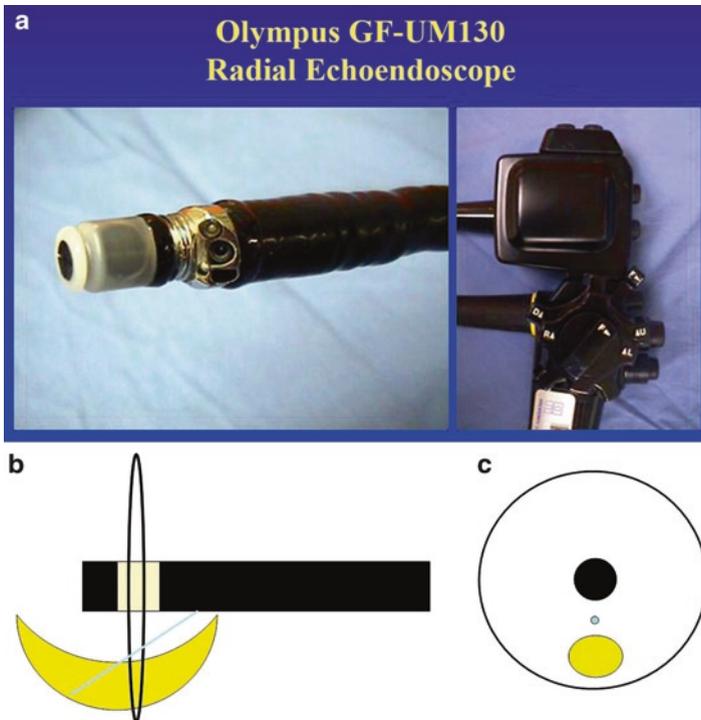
(a–c) Early Olympus mechanical radial-array devices contain a small disc-shaped ultrasound transducer which is attached to a motor drive and rotated in a plane perpendicular to the long axis of the echoendoscope.
